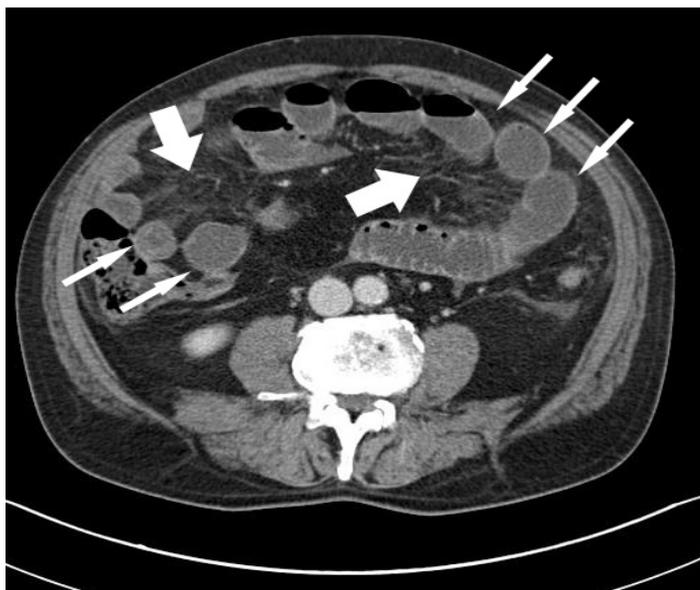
Abdominal CT Transverse Slice Showing Some Free Fluid Around the Ileum (arrow). doi: 10.3834/uij.1944-5784.2010.04.08f1c
